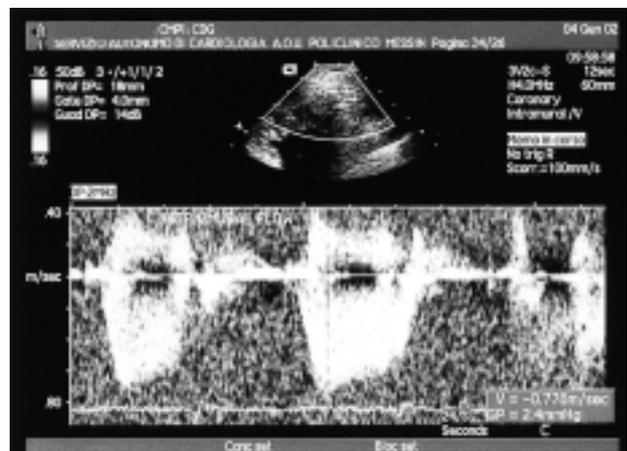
Modified apical 4-chamber view (left panel) in patient B. The distal segment of the epicardial left anterior descending coronary artery and the small intramyocardial coronary artery branches are displayed (arrows). At pulsed-wave Doppler, the diastolic peak velocity (77.6 cm/s) was observed in the largest branch (right panel). No adequate systolic signal is available in this frame. This was also due to the presence of interference by the native epicardial left anterior descending coronary artery signal. Two-dimensional image settings: transducer frequency 4 MHz; depth 80 mm; power spectrum range 32 cm/s; gain 49 dB. COR = intramyocardial coronary branches; EPIC = epicardial coronary artery.
